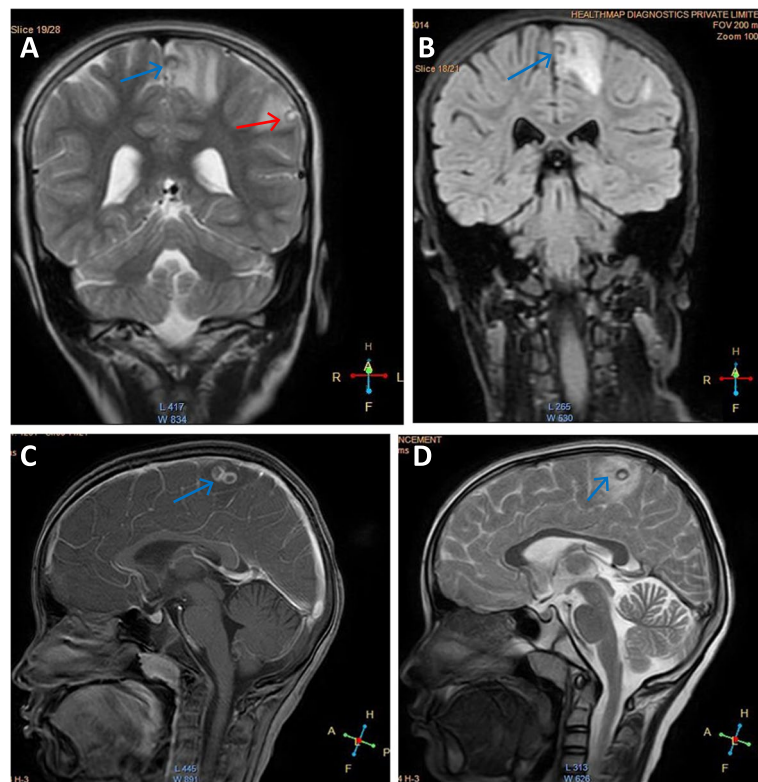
T2 (A, D) and FLAIR (B) images showing two cysts in colloid-vesicular stage in parietal lobe with perilesional oedema. CISS (constructive interference in steady state) sequence (C) show conglomerated lesions with perilesional oedema
